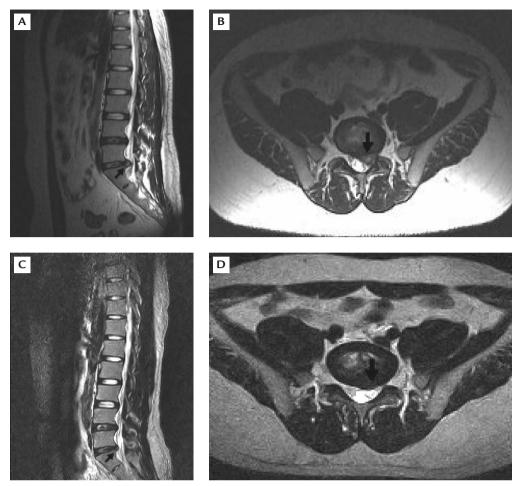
(A) Sagittal T2-weighted imaging (T2WI) of the magnetic resonance imaging (MRI) study revealed a large herniated disc at the L5/S1 level with dural sac compression. (B) Axial T2WI of the MRI study showed a large left-side posterolateral extruded disc fragment at the L5/S1 level. (C) Sagittal T2WI of the second round of MRI showed regression of the herniated nucleus pulposus at the L5/S1 level. (D) Axial T2WI of the second round of MRI showed almost complete regression of the herniated nucleus pulposus at the L5/S1 level without nerve root compression.
